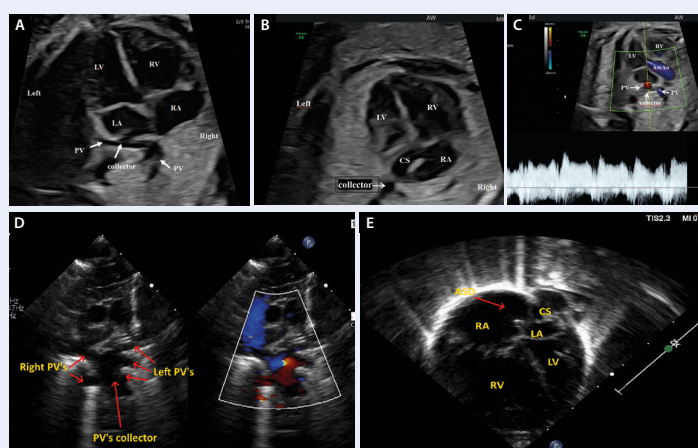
A. Four chamber view at 26 weeks of gestation; the pulmonary veins join a collector visible behind the posterior wall of the left atrium; B. Enlarged coronary sinus at 26 weeks of gestation; C. 26 weeks of gestation; colour Doppler mode; unrestricted blood flow through the collector; D. Postnatal suprasternal view: right and left pulmonary veins draining to pulmonary vein collector. See arrows; E. Postnatal modified 4-chamber view: enlarged right atrium (RA) and right ventricle (RV), small left atrium (LA), compressed left ventricle (LV), CS indicates the point where pulmonary collector connects to coronary sinus, the red arrow shows atrial septal defect position (ASD); Ao — aorta; CS — coronary sinus; PV — pulmonary vein
